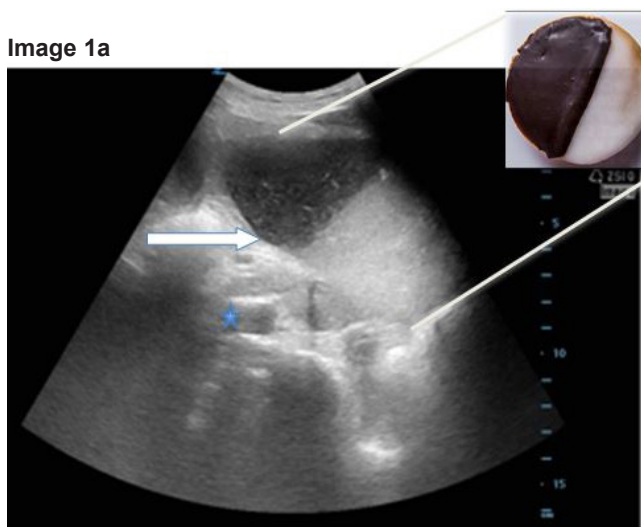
Image 1ab. a) Sagittal orientation point-of-care ultrasound (POCUS) with “black-and-white cookie” sign seen by white arrow with division of stomach contents. Inferior vena cava (blue star) seen distal to the stomach; b) POCUS of dilated, fluid-filled stomach with thickened stomach wall (blue arrow).
